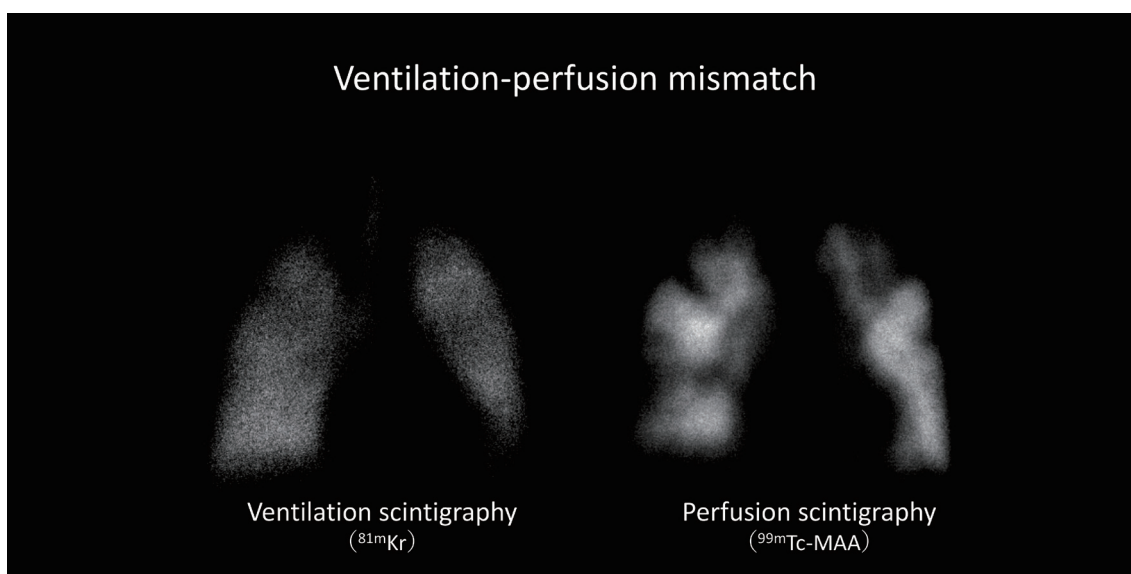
Ventilation and perfusion scintigraphy in patient with CTEPH
